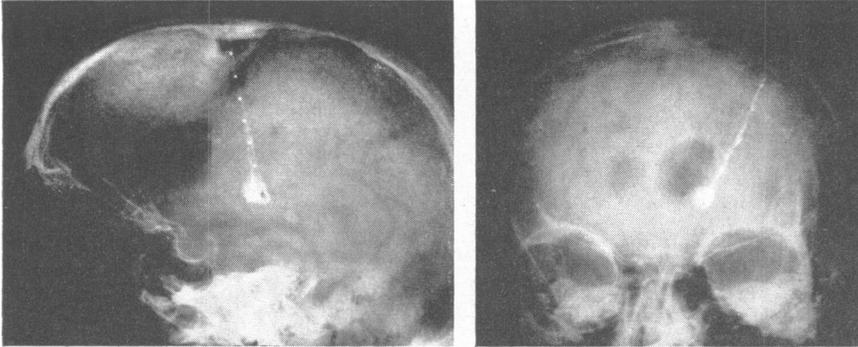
Roentgenographic appearance of thalamic lesion produced in Case II. In our experience this is the lesion of choice for complete alleviation of tremor and rigidity.
